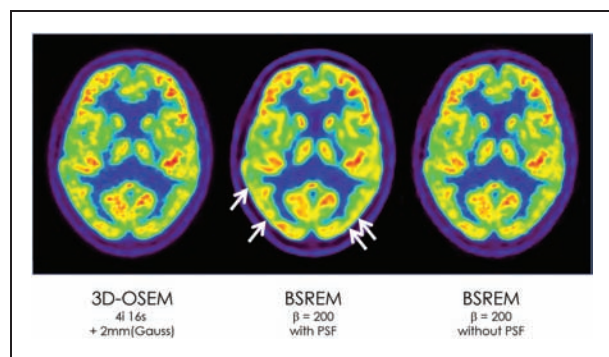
The comparisons of the images of a clinical FDG-PET study (male, 51 y.o., normal volunteer). Unnatural edge artifacts were observed in the images of BSREM with PSF correction.
